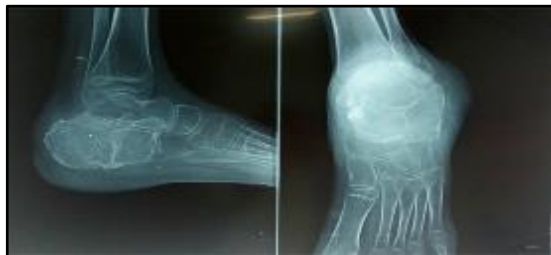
(A & B) Lateral and AP Radiograph of Left Ankle Joint
